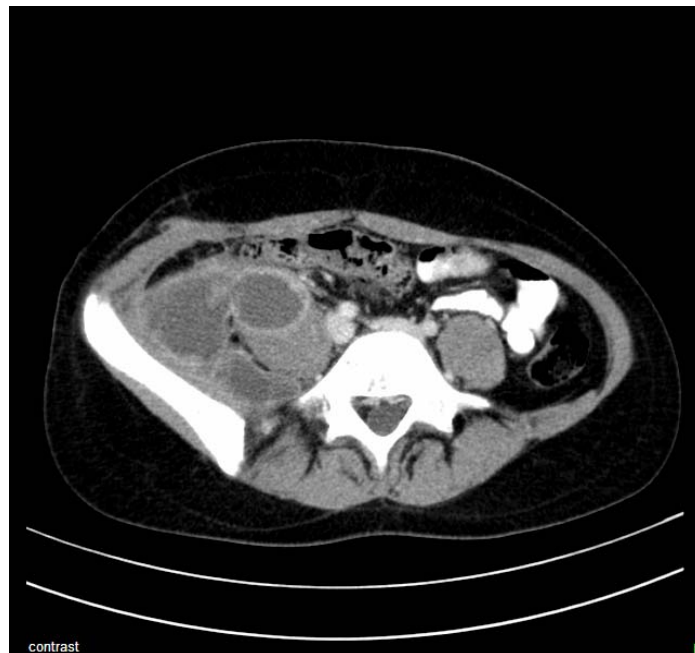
CT scan with contrast, transversal view, showing a gross loculated retroperitoneal collection in the right flank, coming in contact with the iliopsoas muscle which is swollen.*
